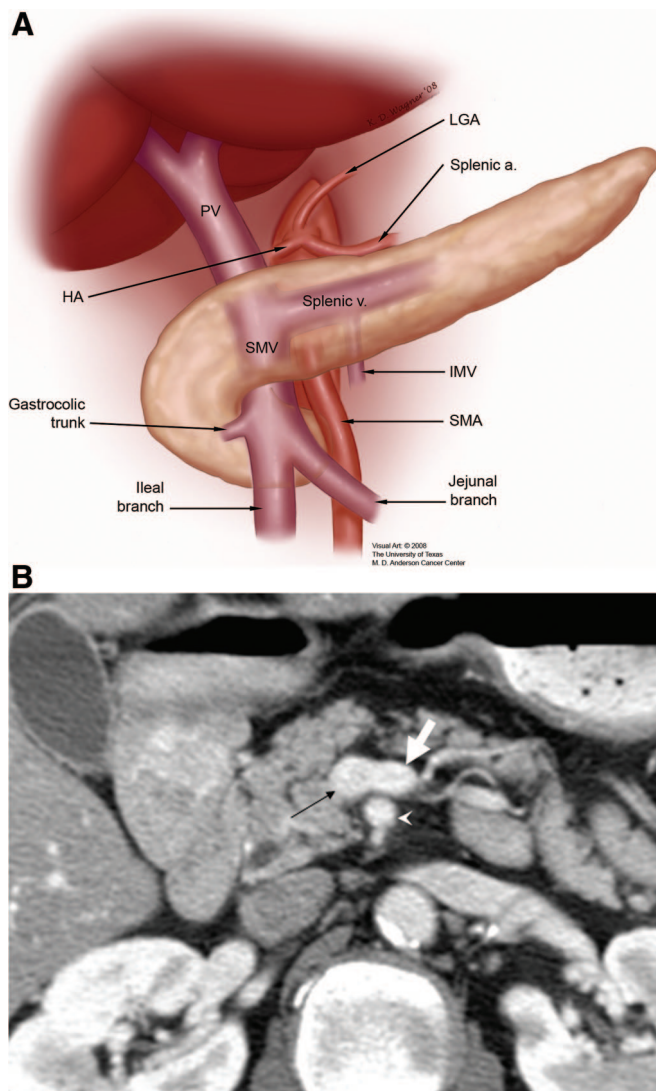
Variant anatomy of the jejunal branch of the superior mesenteric vein (SMV). A, The jejunal branch travels ventral to the superior mesenteric artery (SMA) to drain the proximal small intestine in up to 20% of patients (PV indicates portal vein; HA, hepatic artery; LGA, left gastric artery; IMV, inferior mesenteric vein). B, CT scan depicting the confluence of the jejunal branch and ileal branch of the SMV. The jejunal branch is positioned anterior to the SMA (thin arrow indicates ileal branch of SMV; thick white arrow, jejunal branch of SMV; arrowhead, SMA).
